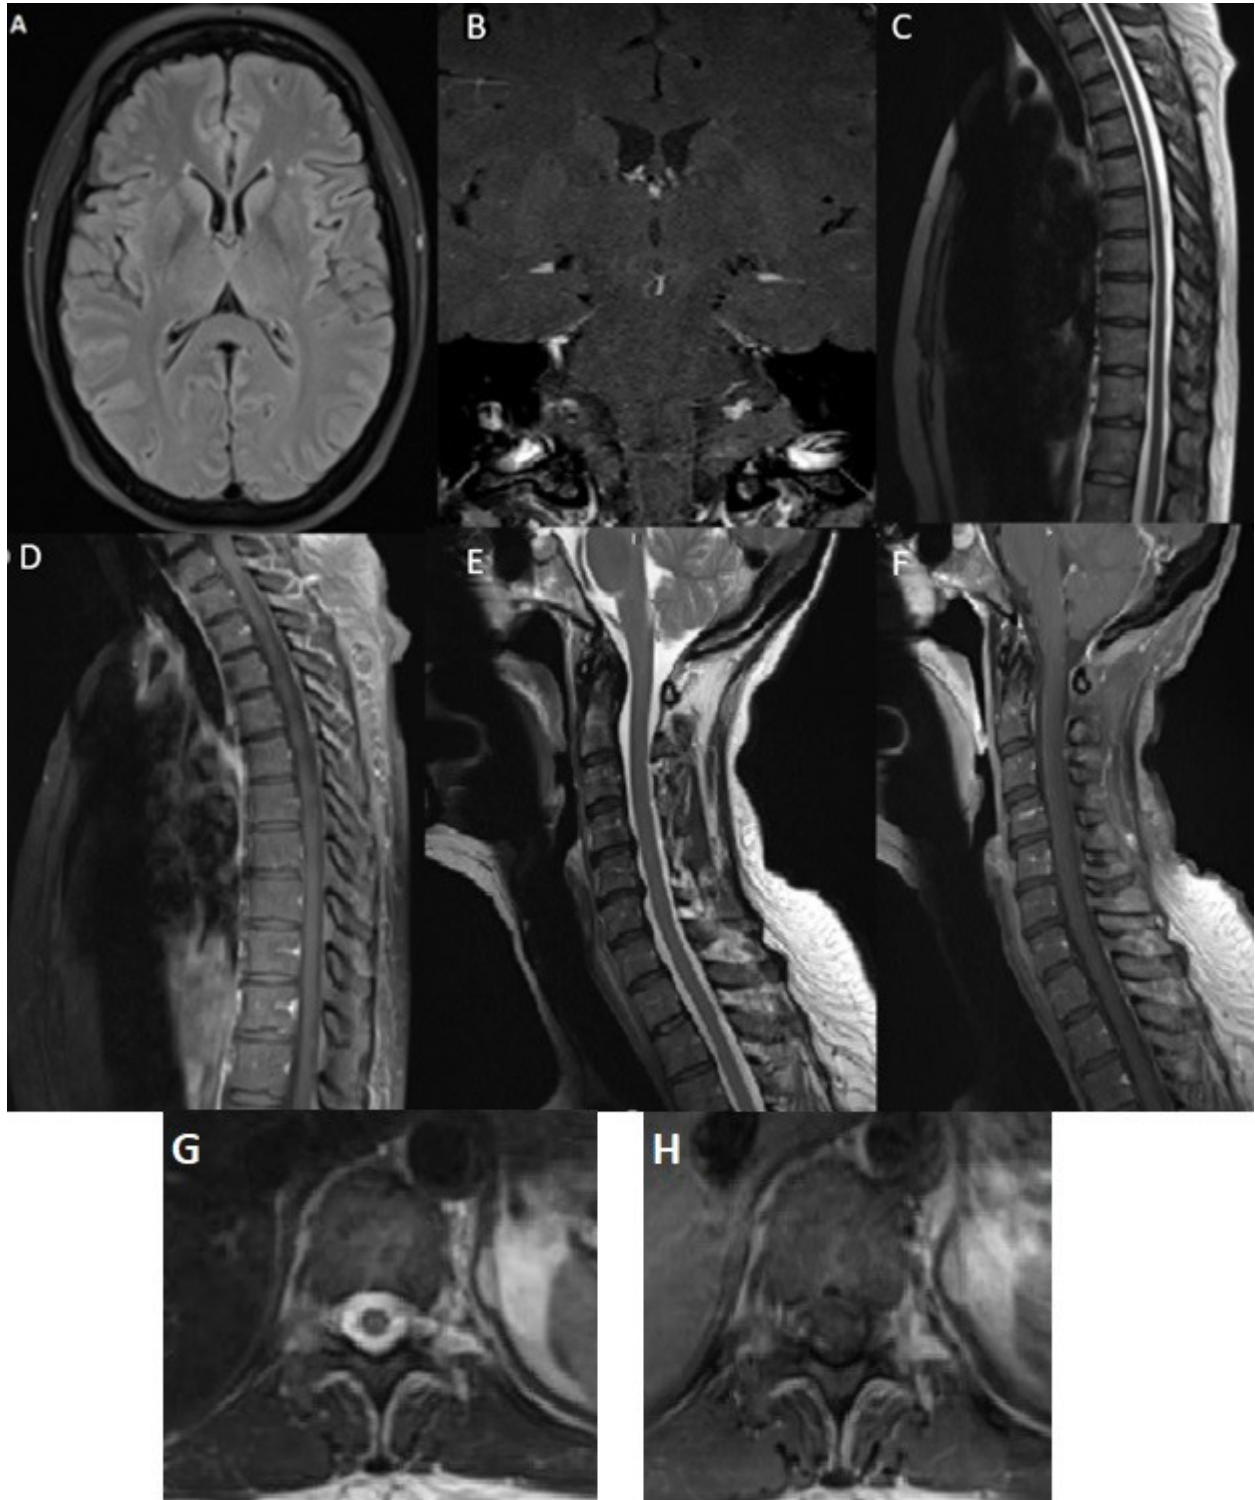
3T MRIs. A) MRI brain w/wo contrast, T2 FLAIR sequence showing several punctate FLAIR hyperintense subcortical bifrontal white matter foci (blue arrows). B) Coronal T1 post-contrast brain MRI with no enhancing lesions. C and D) (C. Sagittal T2, D. Sagittal T1 post-contrast) MRI of the T-spine without cord signal abnormalities or enhancing lesions. E and F) (E. Sagittal T2 and F. Sagittal T1 post-contrast) MRI of the C-spine without cord signal abnormalities or enhancing lesions. G and H) (G. Axial T2 H. axial T1 post-contrast) Axial MRIs of the T-spine at T11 showing no obvious lesions, corresponding to the sensory level on patient's neurologic examination.
